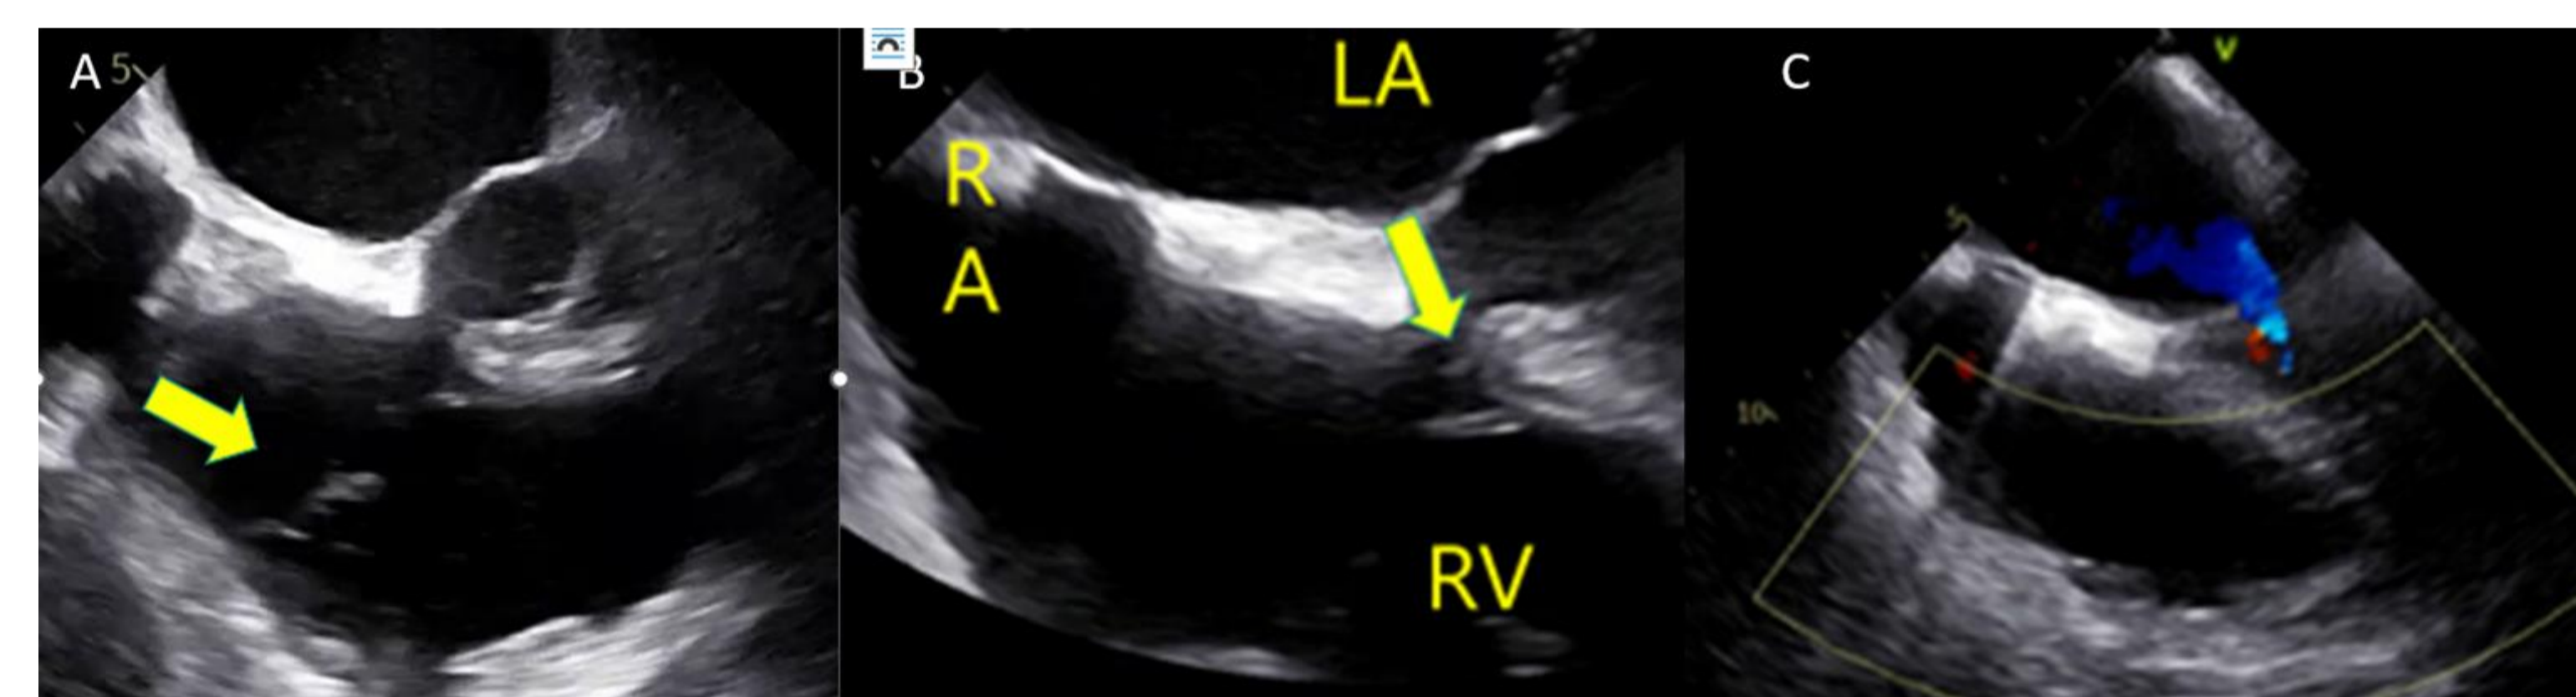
Transesophageal echocardiogram – Mid esophageal 4-Chamber: A. Showing a 2.36 mm vegetation on the anterior tricuspid valve leaflet B. and on the septal tricuspid valve leaflet. C. Color flow Doppler showing tricuspid regurgitation with central jet
